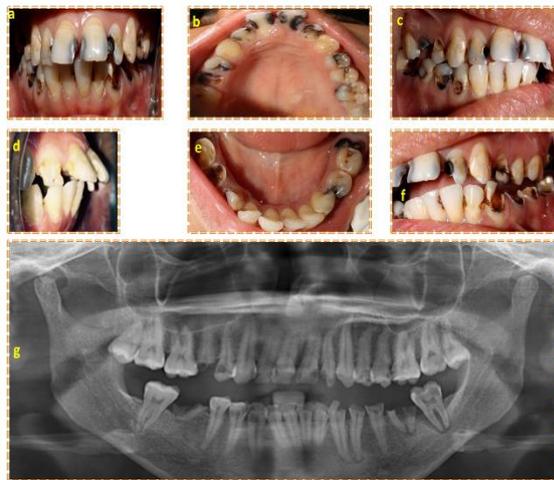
Intra oral view of maxillary and mandibular dentition (a-f) and Orthopantomograph (g)
